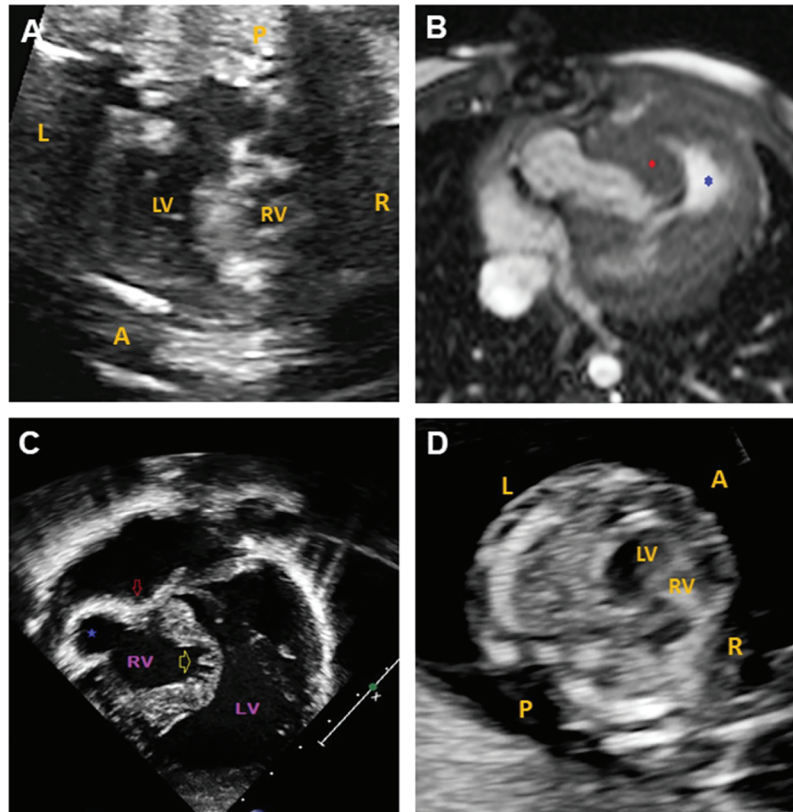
Cardiac imaging for the paediatric case and fetal sibling. (A) 26-week fetal echocardiogram for the paediatric patient showing a hypoplastic RV. (B) Cardiac MRI for the paediatric patient at birth. Axial balanced steady state gradient echo (TRUFISP). Severe tricuspid valve stenosis with RV anterior free wall ballooning (blue star) and hypertrophied moderator band (red diamond). (C) Echocardiography for the paediatric patient at birth. Apical view with severe tricuspid stenosis (red arrow), RV anterior free wall ballooning (blue star), and atrophic and trabecular inter-ventricular septum. (D) 13-week fetal echocardiogram showing a hypoplastic RV in the fetal sibling. L: left, R: right, A: anterior, P: posterior, LV: left ventricle, RV: right ventricle
